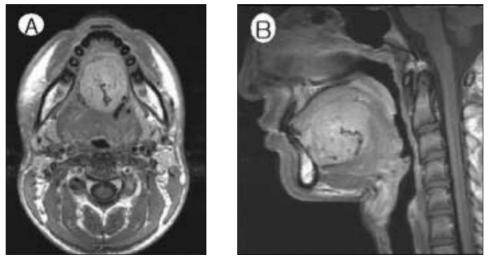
Postcontrast T1-weighted axial and sagittal images show intense enhancement with numerous feeding vessels. Signal void structures are once again seen.
